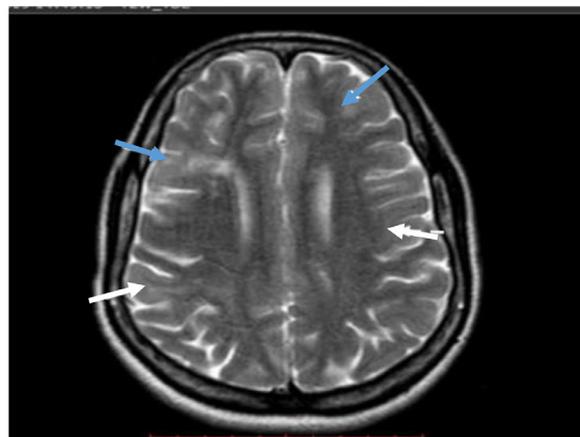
MRI Brain shows flame-shaped cortical tubers (blue arrows) in bilateral frontal lobes (solid arrows) and bilateral parietal lobes (white arrows) on hyperintense on T2W image.
